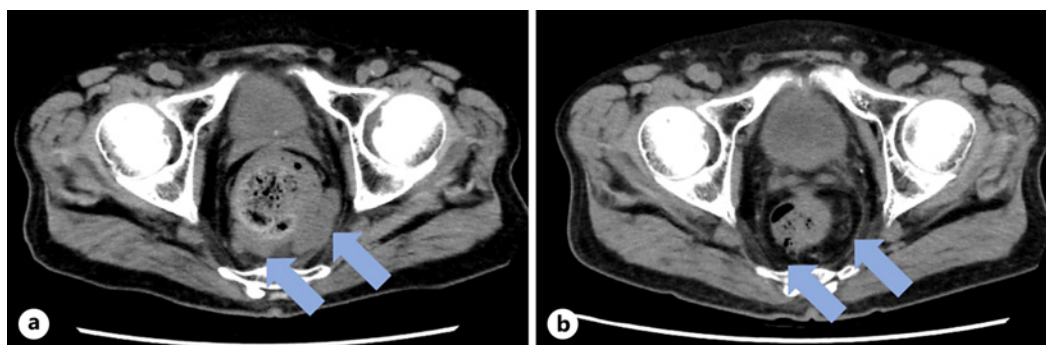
Axial non-contrast CT. The pre-pembrolizumab (a) and post-pembrolizumab (b) statuses.
